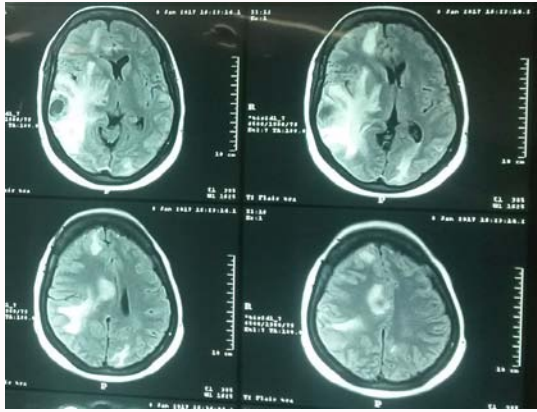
MRI showing *T.gondii* lesions.
